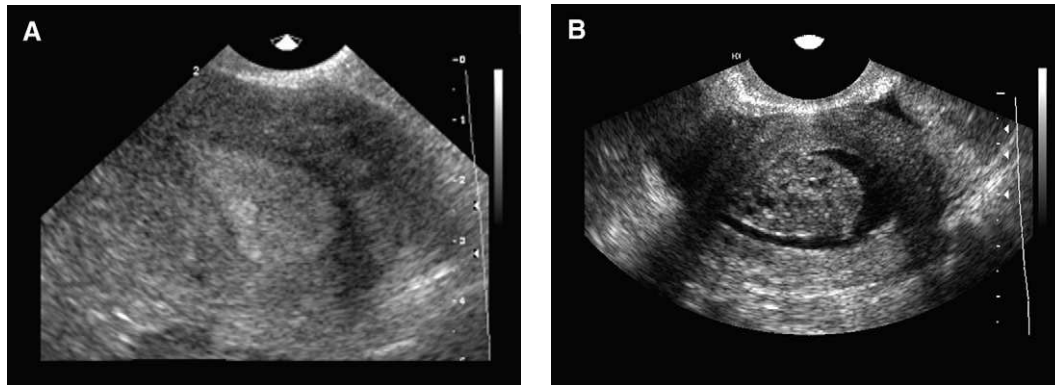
(A) Mid-sagittal ultrasound image demonstrates a slightly heterogeneous thickened endometrium. (B) Sonohysterogram image demonstrates a pedunculated heterogeneous mass consistent with a polyp (and less likely a fibroid).
